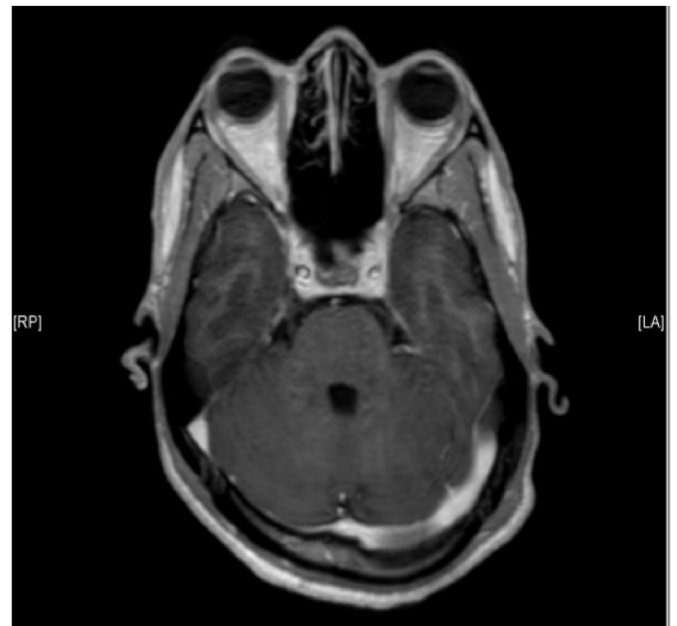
Brain sagittal MRI 3D T1 FFE with gadolinium injection: Left cerebellar contrast enhancement evoking a micro-abscess (arrow) [Image 4a](#) which disappears at control at 12 months. [Image 4b](#).
